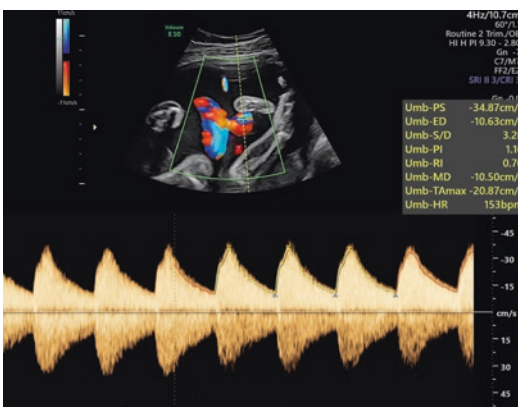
An example of mirror imaging of the Doppler waveform. Doppler waveforms from the umbilical artery are displayed above the baseline. The vertical line is the cursor representing the beam path. The Doppler sample volume (two short horizontal lines) is placed in the umbilical artery. The mirror image is seen on the reverse side of the baseline
